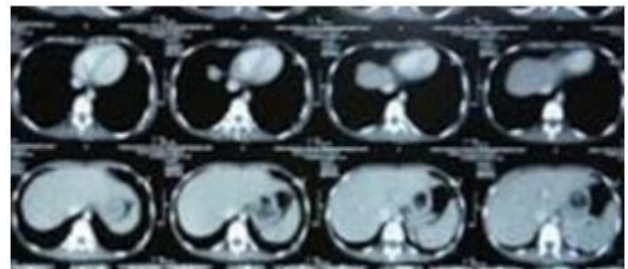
A contrast enhanced CT scan of upper abdomen showing a lobulated opacity with trapped air foci within occupying the lumen of fundus, body and antrum of stomach measuring 15 x 4.5 cm, possibility of trichobezoar.
